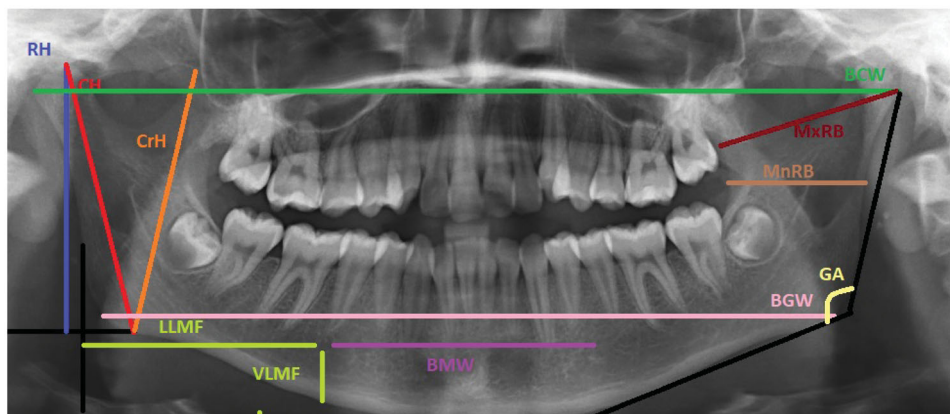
Digital orthopantomograph showing assessed mandibular variables. RH: Ramus height; CH: Condylar ramus height; CrH: Coronoid ramus height; MxRB: Maximum ramus breadth; MnRB: Minimum ramus breadth; BGW: Bigonial width; BCW: Bicondylar width; BMB: Bimental width; LLMF: Lateral length of mental foramen; VLMF: Vertical length of mental foramen; GA: Gonial angle.
